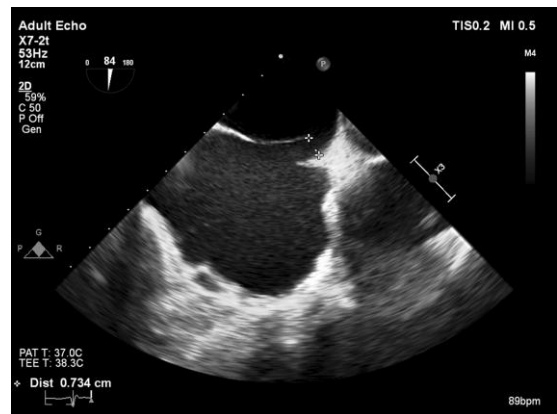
Transesophageal echocardiography – visible patent foramen ovale canal – 7 mm.
